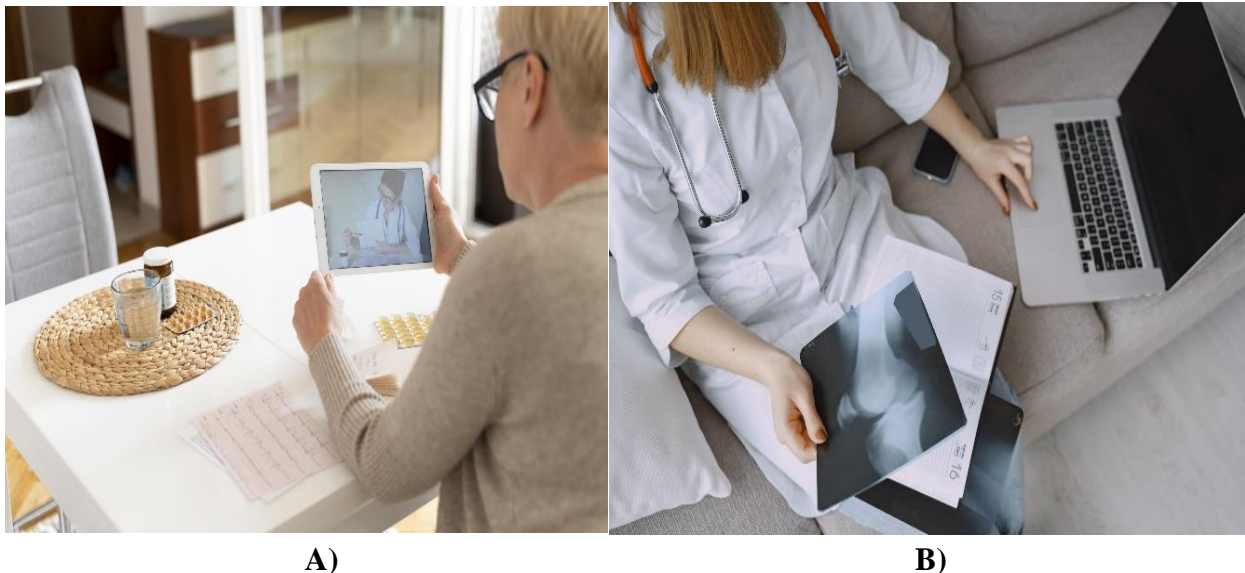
A) The process of remote patient monitoring (X-rays) B) Real-time online monitoring
